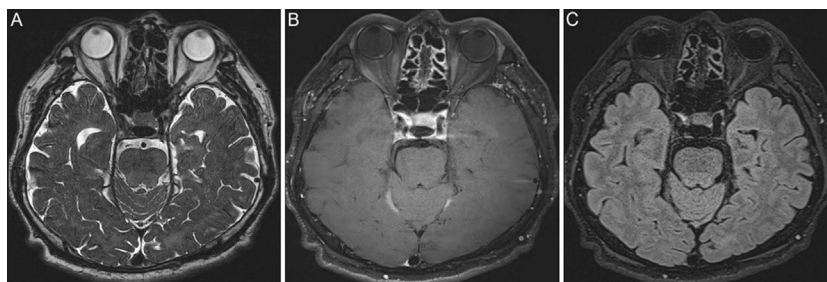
Orbit magnetic resonance imaging of a 79-year-old male patient with non-arteritic ischemic optic neuropathy (Case 2) Axial T2-weighted SPACE imaging demonstrating no definite optic disc swelling at the right optic disc (A). Axial 3D contrast-enhanced T1-weighted image shows a focal contrast enhancement at the right optic disc (B), which is more conspicuous on contrast-enhanced 3D T2-fluid-attenuated inversion recovery image (C).
